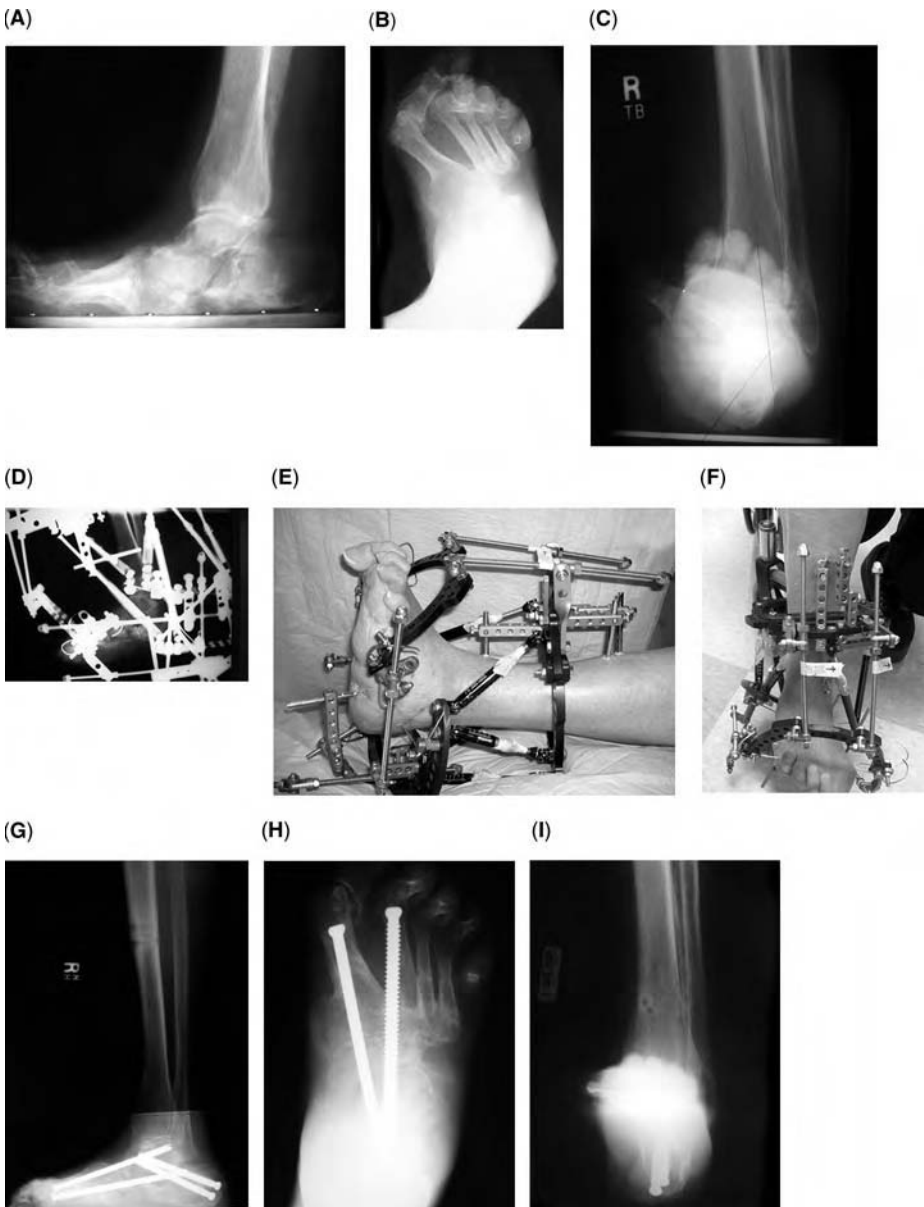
Case of midfoot Charcot neuroarthropathy with hindfoot equinovarus deformity (Eichenholtz stage 3, stable, with superficial ulceration and previously removed osteomyelitis). (A) Lateral view radiograph shows rocker-bottom and equinus deformities. (B) Anteroposterior view radiograph shows midfoot adduction deformity. (C) Axial (Saltzman) view radiograph shows hindfoot varus deformity. A percutaneous Achilles tendon Z-lengthening was performed to aid the hindfoot correction before applying the external fixator. However, complete equinus correction was not achieved acutely. A percutaneous midfoot Gigli saw osteotomy was performed across the neck of the calcaneus and talus. A Taylor spatial frame (long bone) was used for gradual soft-tissue correction of the hindfoot (equinovarus) while the forefoot was gradually corrected with the use of an Ilizarov apparatus through the midfoot osteotomy. (D) Lateral view postoperative radiograph shows the midfoot osteotomy with the external fixator in place. The hindfoot equinus deformity was corrected first through gradual soft-tissue realignment. The external fixator was then modified while the patient was in the clinic by backing out the half-pin that crossed the sinus tarsi into the talus so that the half-pin was located only in the calcaneus. The hindfoot varus deformity was then gradually corrected through the subtalar joint. (E) Lateral view and (F) anteroposterior view clinical photographs show the Ilizarov pusher and puller rods that were used to gradually correct the rockerbottom and adduction midfoot deformities. External fixation was removed after realignment was achieved. Immediately after removal of the fixator, a minimally invasive fusion of the midtarsal and subtalar joints was performed with the use of intramedullary metatarsal cannulated screws inserted percutaneously. (G) Lateral view radiograph shows the patient during weight bearing. (H) Anteroposterior view radiograph shows the patient during weight bearing. (I) Axial view radiograph shows the patient during weight bearing. Note the accurate anatomic reduction. The patient has not experienced recurrence of ulceration or deformity (three-year follow-up).
